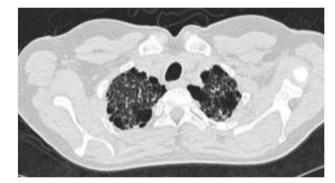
and b shows the fibrotic changes seen in his HRCT-scan.
